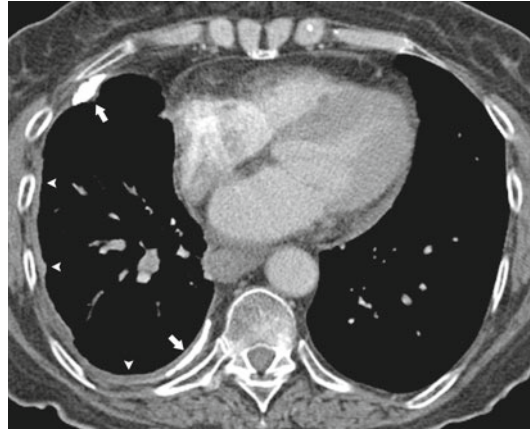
Radiation-induced pleural thickening. Contrast-enhanced CT scan shows diffuse right pleural thickening (*arrowheads*) with calcification (*arrows*)
